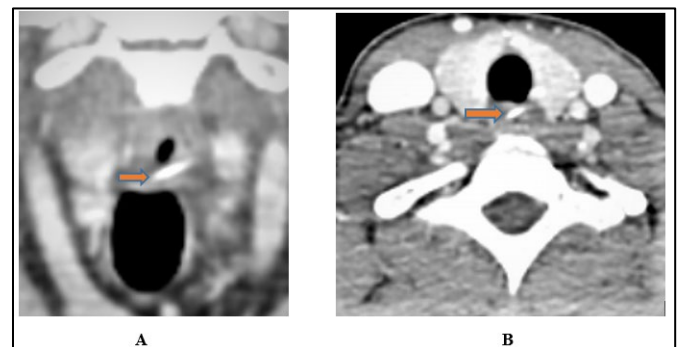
CT showed a linear hyperdense FB (1.4 cm in length) at the anterior wall of oesophagus as visualized in coronal (A) and axial view (B)
